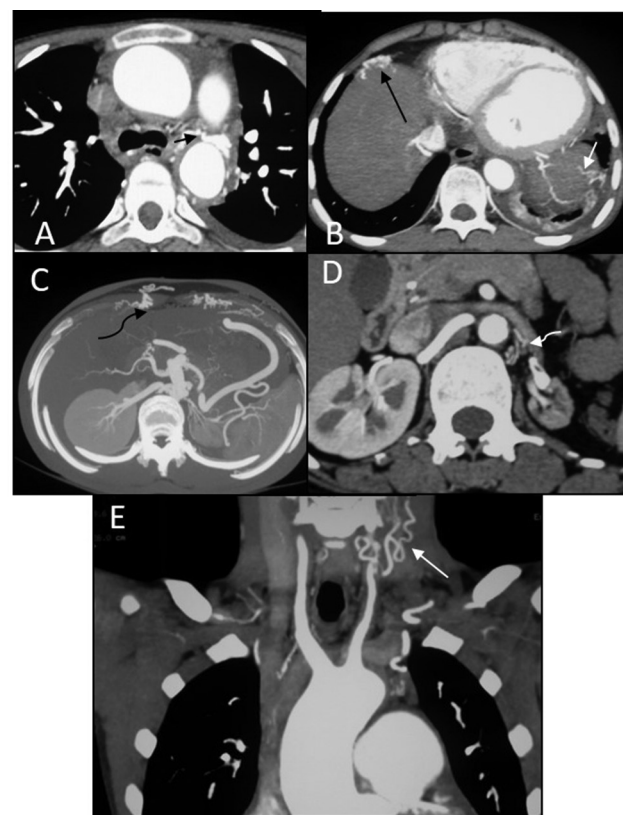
Multiple collateral vessels are seen in various patients in CT angiographic images: aortopulmonary (A, short black arrow), left phrenic (B, small white arrow), anterior perihepatic (B, large white arrow), anterior abdominal wall (C, curved black arrow), left cervical collaterals (E, large white arrow are seen). (D) This shows paravertebral collaterals replacing left renal artery in a case (curved black arrow).
